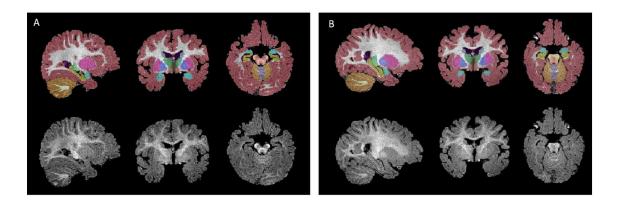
Post-processed T1-weighted MRI scans that were segmented using infant Freesurfer in (A) a high-risk infant who was later diagnosed with ASD and (B) a highrisk infant who did not receive an ASD diagnosis.
